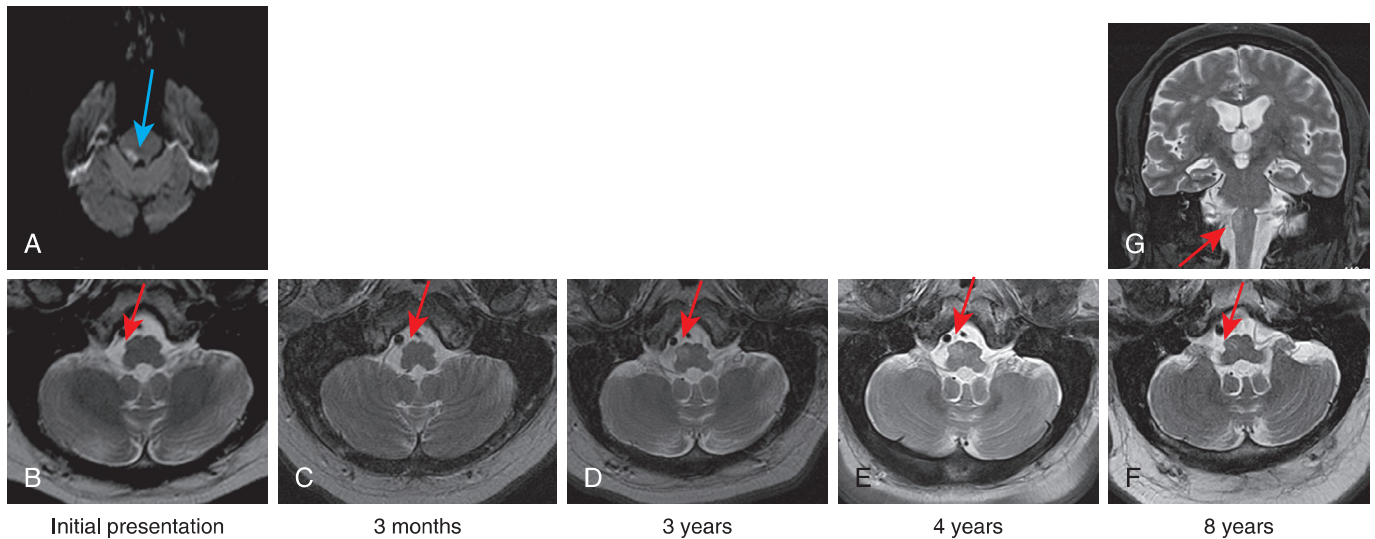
Temporal evolution of hypertrophic olivary degeneration (HOD) in a 62-year-old patient with brainstem stroke and subsequent oculopalatal myoclonus. At the time of initial presentation, an axial DWI image (A) through the pons demonstrates an acute infarct (*blue arrow*) involving the right superior cerebellar peduncle. Axial T2 images through the level of the medullary olive at the time of presentation (B) and 3 months later (C) demonstrate normal signal intensity and size of the right olive (*red arrows*). Axial T2 images at 3 years (D) and 4 years (E) demonstrate interval development of right olivary T2 hyperintensity and hypertrophy consistent with HOD (*red arrows*). At 8 years, axial (F) and coronal (G) T2 images demonstrate nearly complete resolution of hypertrophy with residual T2 hyperintensity (*red arrows*).
